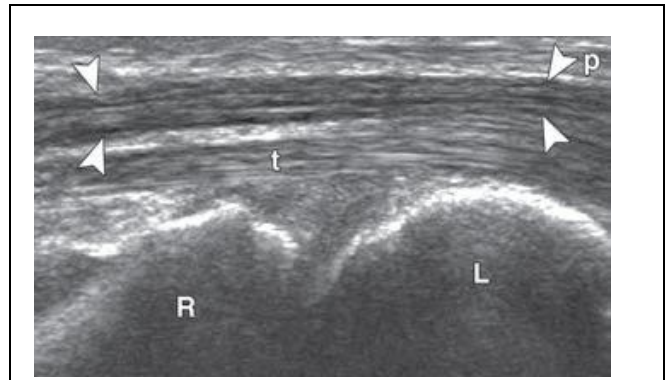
44-year-old man in excellent health and normal sonographic anatomy
